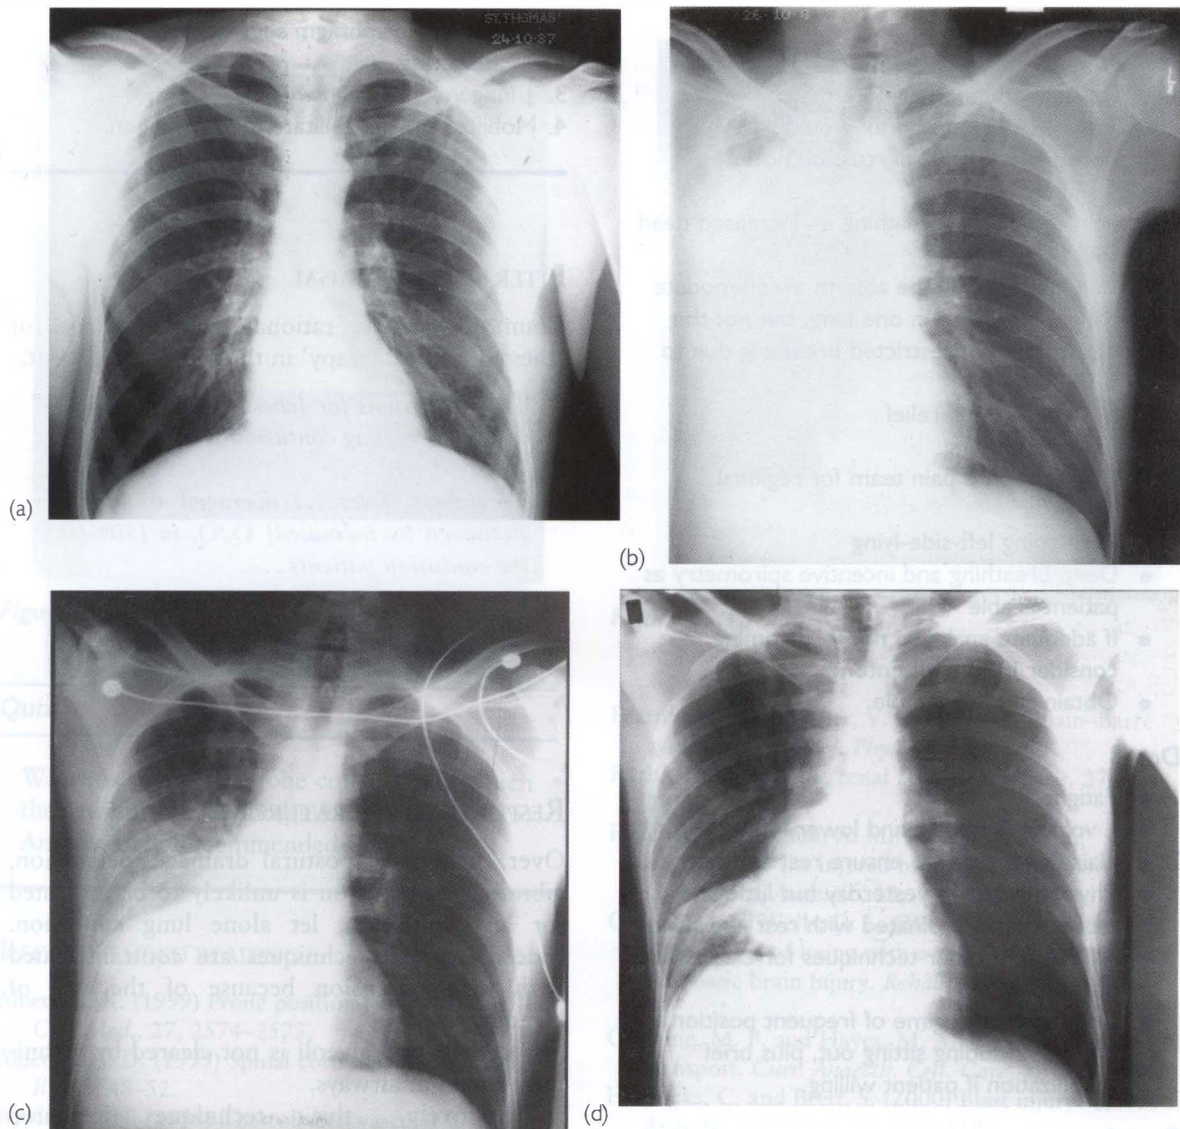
X-rays of Mr CA. (a) Day 1. (b) Day 2. (c) Day 3. (d) Day 4.
